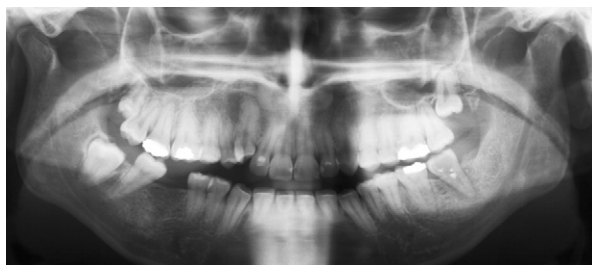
Radiograph showing the periapical pathosis of the second left mandibular molar.
